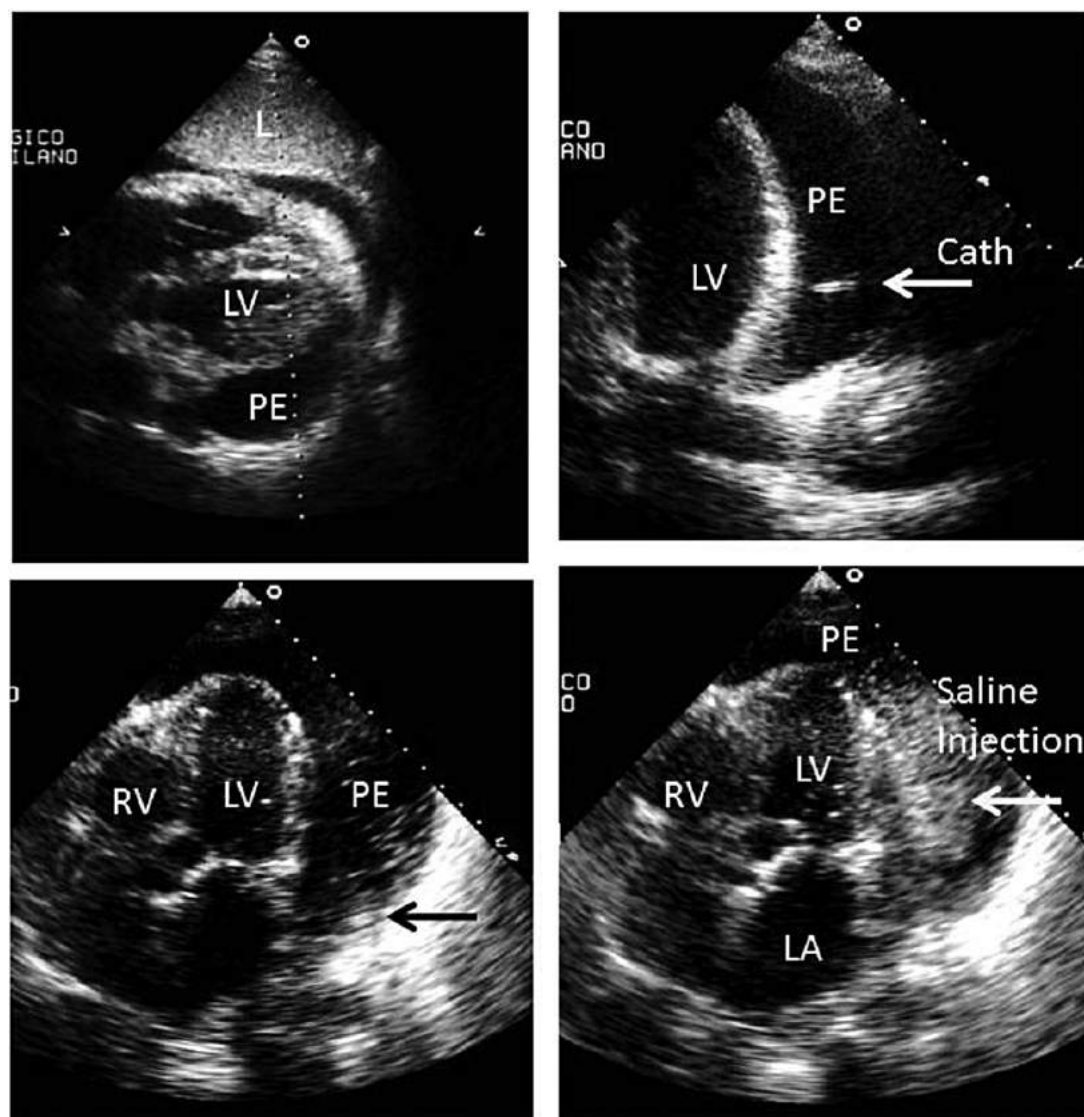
Echocardiography without and with contrast injection before pericardiocentesis. RV, right ventricle; LV, left ventricle; LA, left atrium; PE, pericardial effusion; Cath, drainage catheter; L, leaver.
